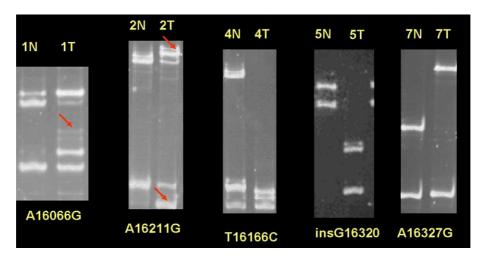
Representative single-strand conformation polymorphism (SSCP) analysis gel radiographs from the five cases with somatic D-loop mitochondrial (mt) DNA mutations. The "banding" pattern was shown in paired normal (N) and tumour (T) samples. Arrows indicate band shifts. The specific mutation is indicated below the five tumour samples.
